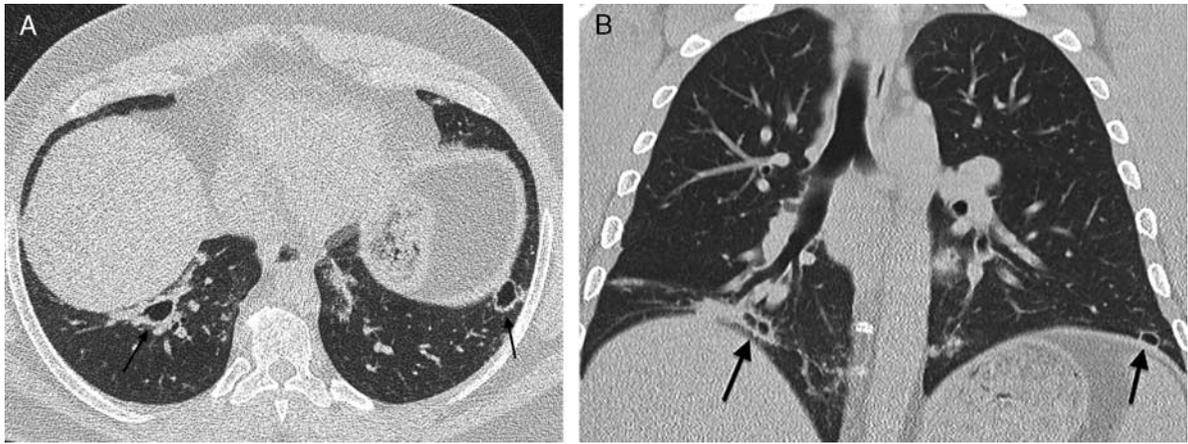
Imaging results of a 39-year-old man with WTC-related sarcoidosis. A, Axial 1 mm HRCT image demonstrating small cavities at both lung bases (black arrows). B, Coronal 5 mm CT image demonstrating small cavities at both lung bases (black arrows), in a patient with atypical basilar disease distribution. PFTs demonstrated obstructive physiology.
